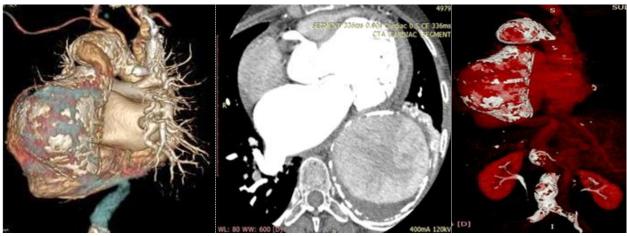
CT CAG revealing near total occlusion of LMCA with thinned out and diseased LCX with distal LAD being filled by collaterals
